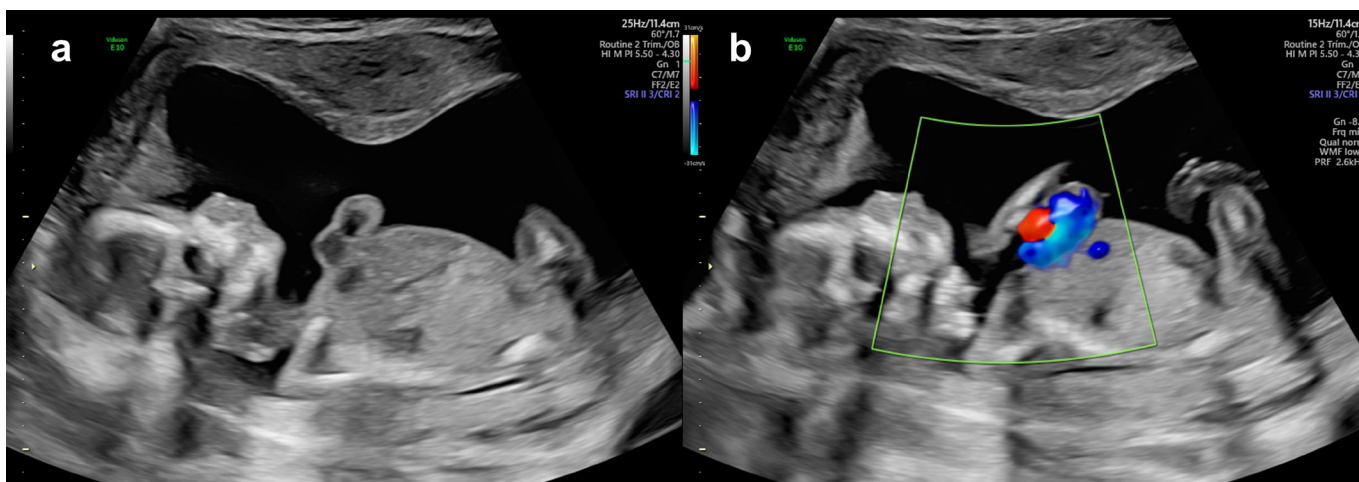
Prenatal ultrasound of the foetus with thoracic ectopia cordis in longitudinal section. (a) Without colour-Doppler; (b) With colour-Doppler.
